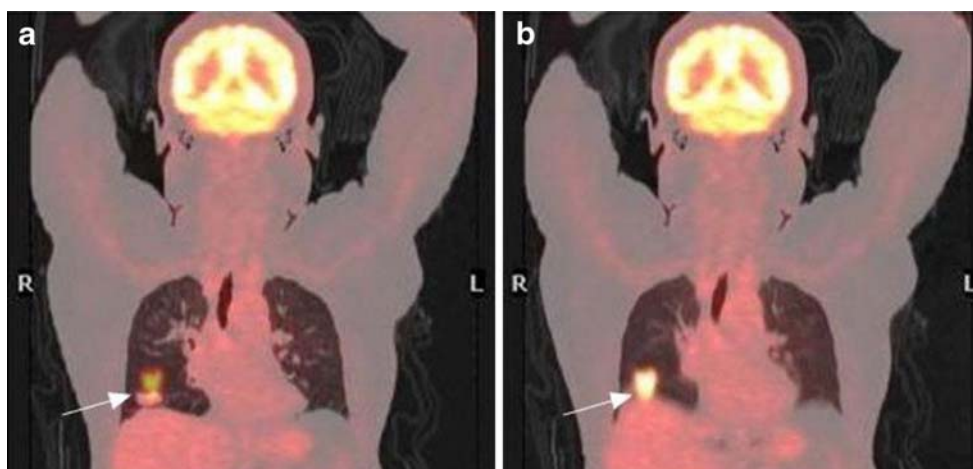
Prominent misregistration. A 66-year-old male patient underwent a PET/CT scan for restaging of squamous cell lung carcinoma of the right lower lobe. Prominent misalignment of the image is apparent in the PET/HCT image (a) but this is corrected in the PET/ACT image (b). The tumour SUV_{max} in PET/HCT image was 7.4 (a) and 10.8 in PET/ACT (b)
